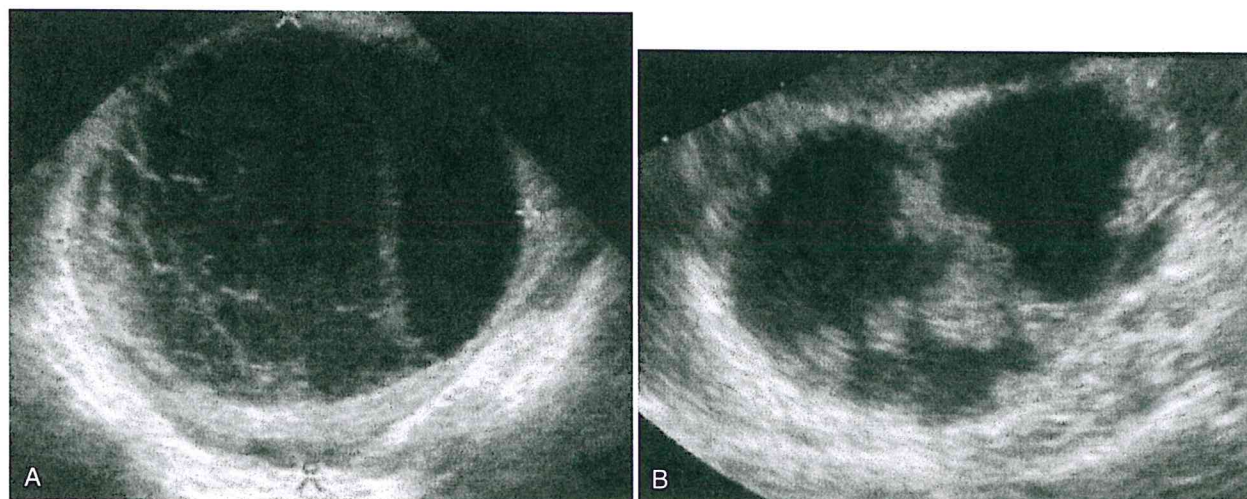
Ultrasound evaluation of benign and malignant ovarian cysts. A, Hemorrhagic smooth-walled cyst. B, Ovarian cancer with irregular wall thickness, lining surface, and septation. (Courtesy of Beryl Bennaceraf, Boston, MA.)
